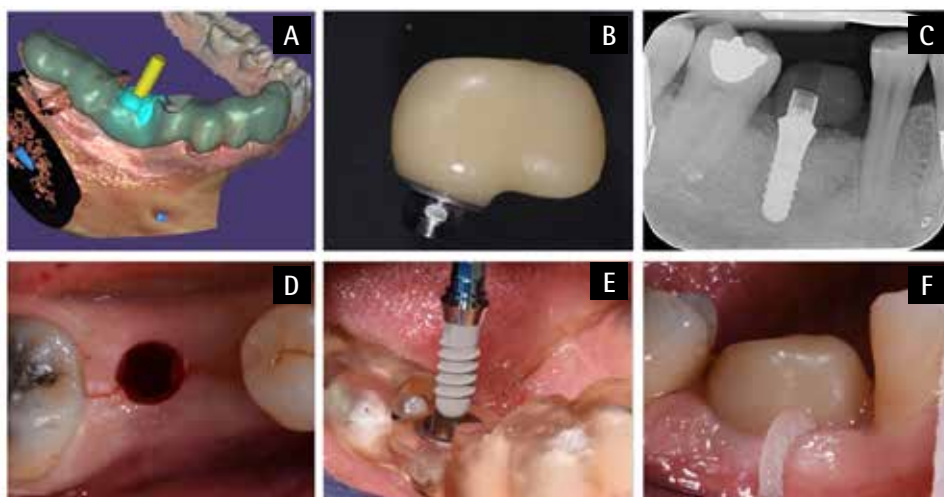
Surgical procedure: surgical template project (A); milled customized healing abutment (B); Periapical radiography after with customized healing abutment fixed to the implant (C); intraoral view of the flapless approach (D); implant insertion through the surgical guide (E); intraoral view of the customized healing abutment fixed to the implant and access for hygiene (F).
